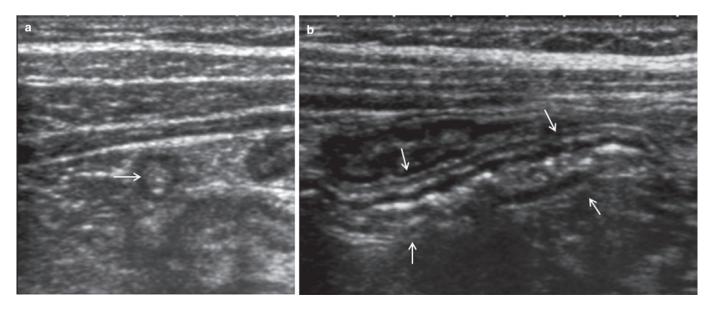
Ultrasound image showing (a) transverse and (b) longitudinal section of a normal appendix (white arrows). The patient was included in group 1.
